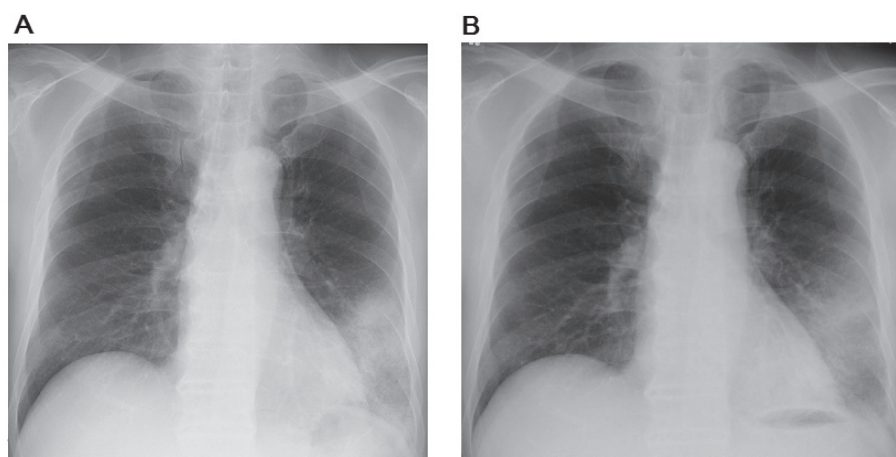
(A) Chest radiograph on admission shows a non-segmental infiltration shadow in the left lower lung field. (B) Chest radiograph on day 4 after admission shows improvement of the infiltration shadow in the left lower lung field.
